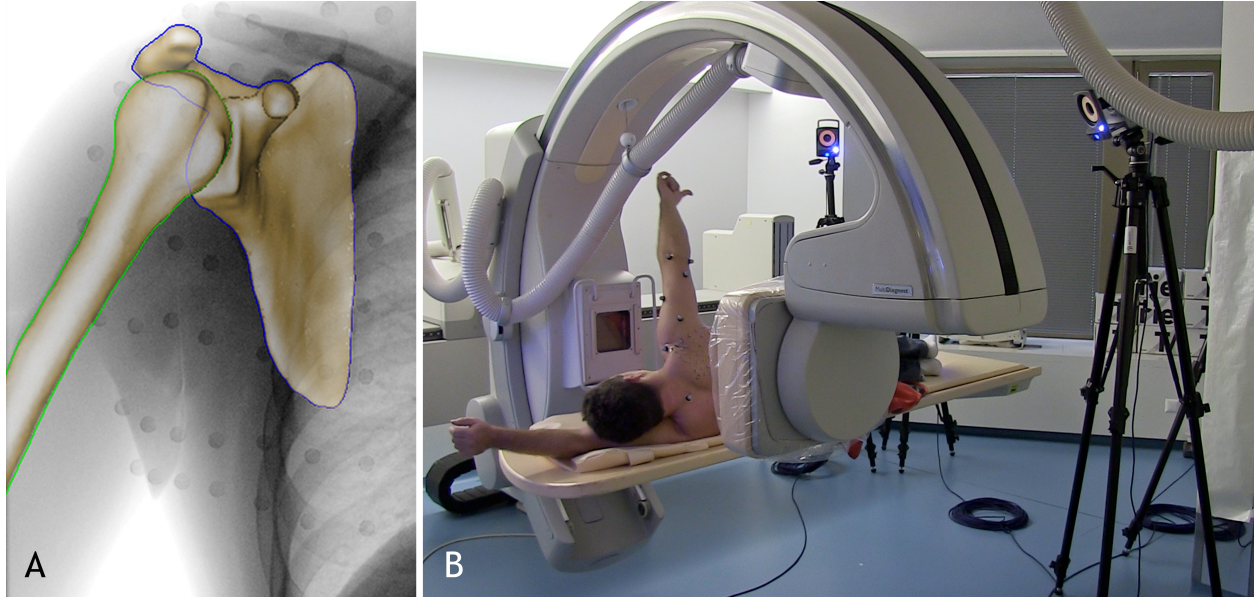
A) 3D-to-2D shape matching technique. Image from [CCK⁺14] used with permission. B) Simultaneous motion capture and X-ray fluoroscopy of the shoulder joint.
